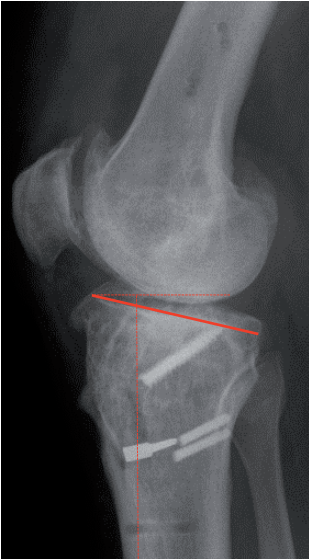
Radiograph of knee (lateral view) after failed distraction treatment with posterior tibial slope $>15^\circ$.
